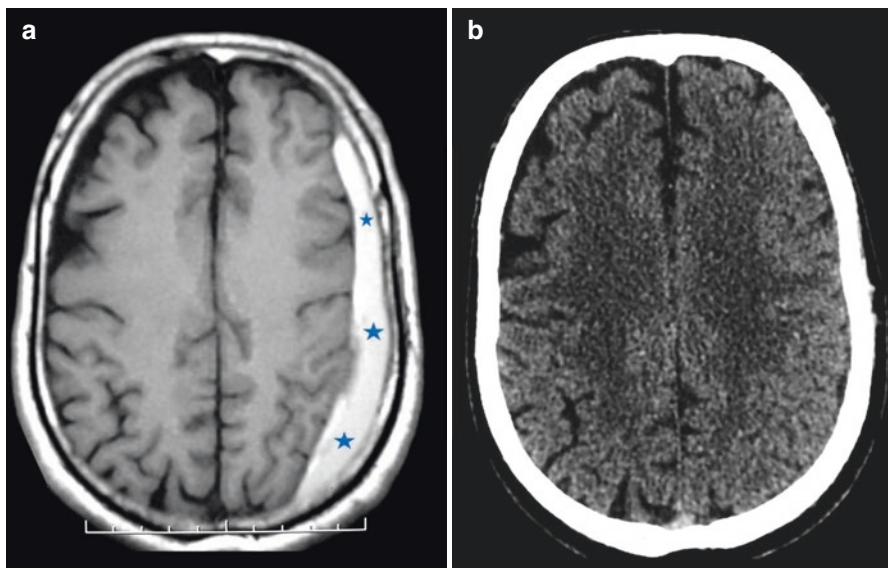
Paucisymptomatic 53-year-old man with an intracranial left chronic SDH on T1-weighted MRI (a). This patient was treated by corticosteroids (hydrocortisone) and oral rehydration for 8 weeks. Control CT scan (at the end of the second month following the initial MRI) revealing the complete regression of the subdural collection (b)
